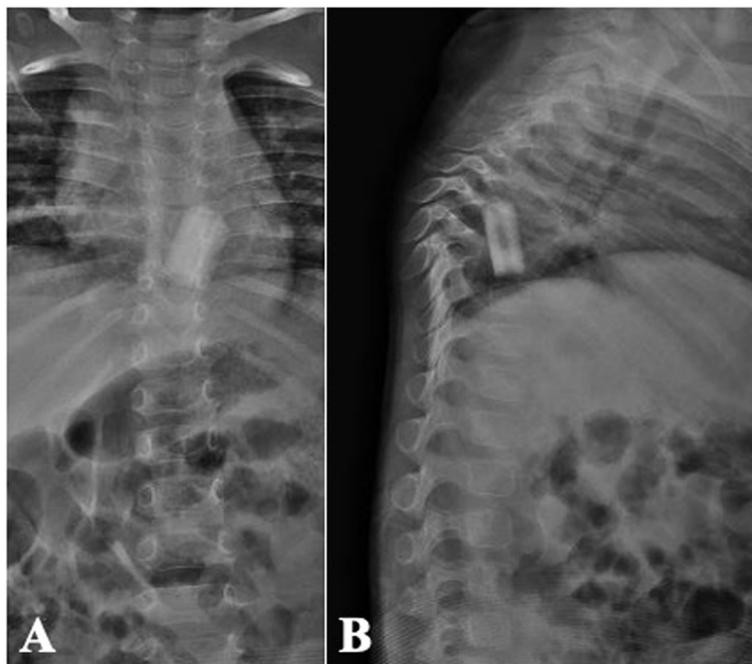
A Ap view and B lateral view of a dorsal spine radiograph 12 months after the surgery with fibula allograft between vertebrae D6 and D9
